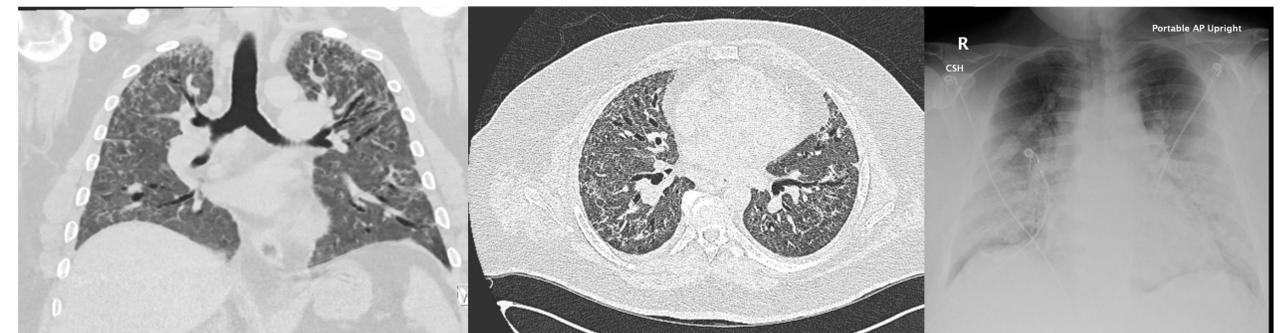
Unenhanced coronal CT through the level of the carina showing diffuse interstitial thickening and traction bronchiectasis in a pattern consistent with fibrosis. High resolution axial CT through the heart shows the same. Corresponding CXR shows mixed interstitial and airspace opacities.
